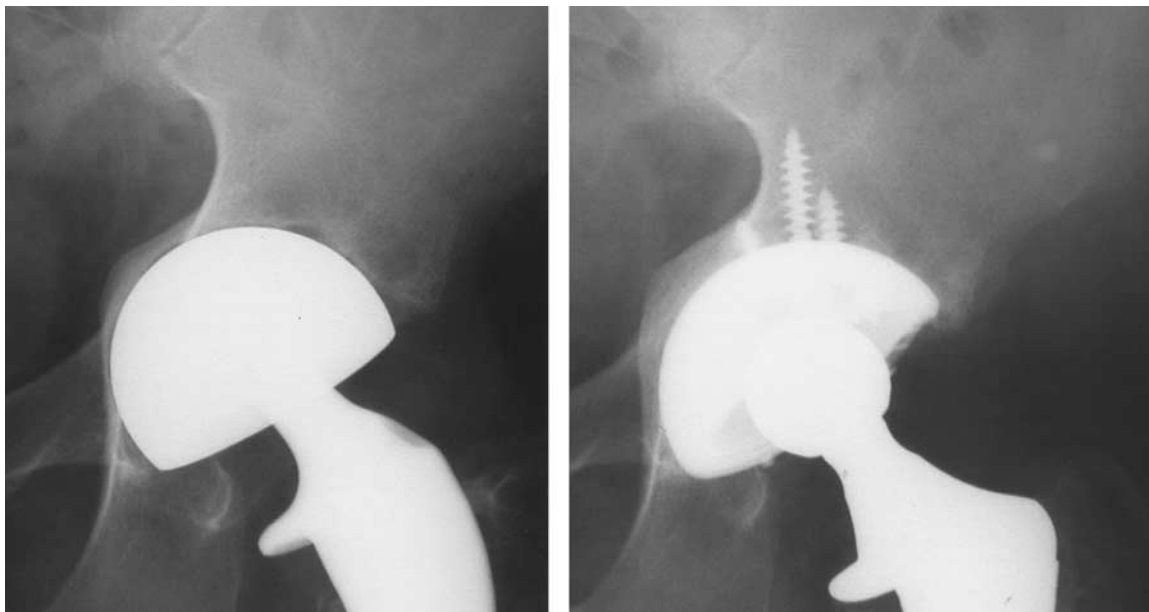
(A) Prerevision radiograph shows characteristic acetabular osteolysis. (B) Conversion to THA with standard cementless hemispherical sockets.
